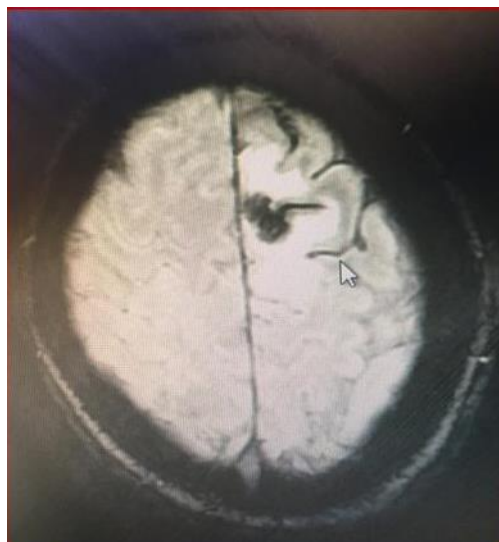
MRI Brain: A small well defined lesion in left high frontal region
